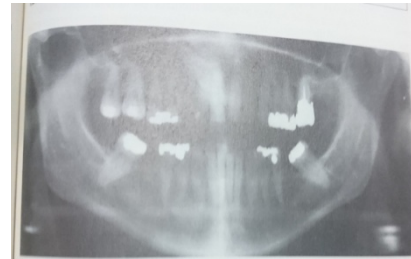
Panoramic radiograph of 9yrs old female
